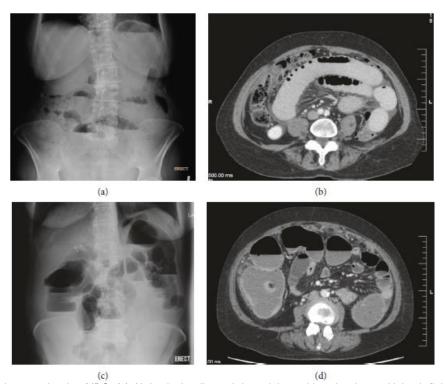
Radiographic images showing MBO. (a) Abdominal radiograph in upright position showing multiple air-fluid levels consistent with small bowel obstruction (SBO). (b) Computed tomography (CT) confirms a high-grade SBO. (c) Abdominal radiographs in upright position showing large bowel obstruction (LBO). (d) CT demonstrates distended and fluid-filled large bowel loops concordant with LBO [1].
